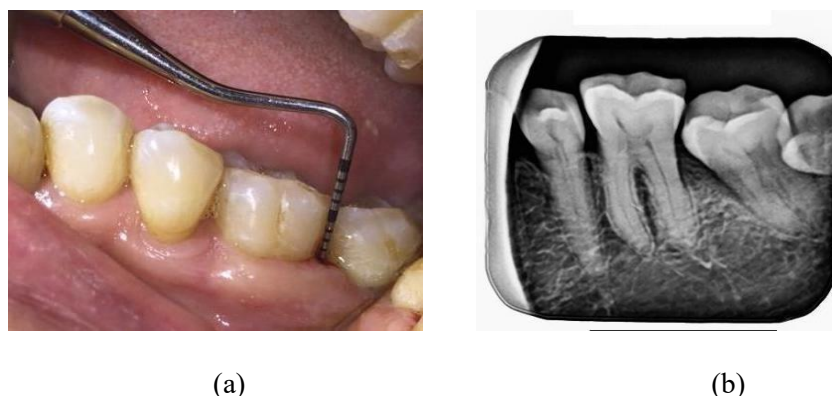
Pre-Treatment Clinical view a. Clinical view b. Radiographic view
